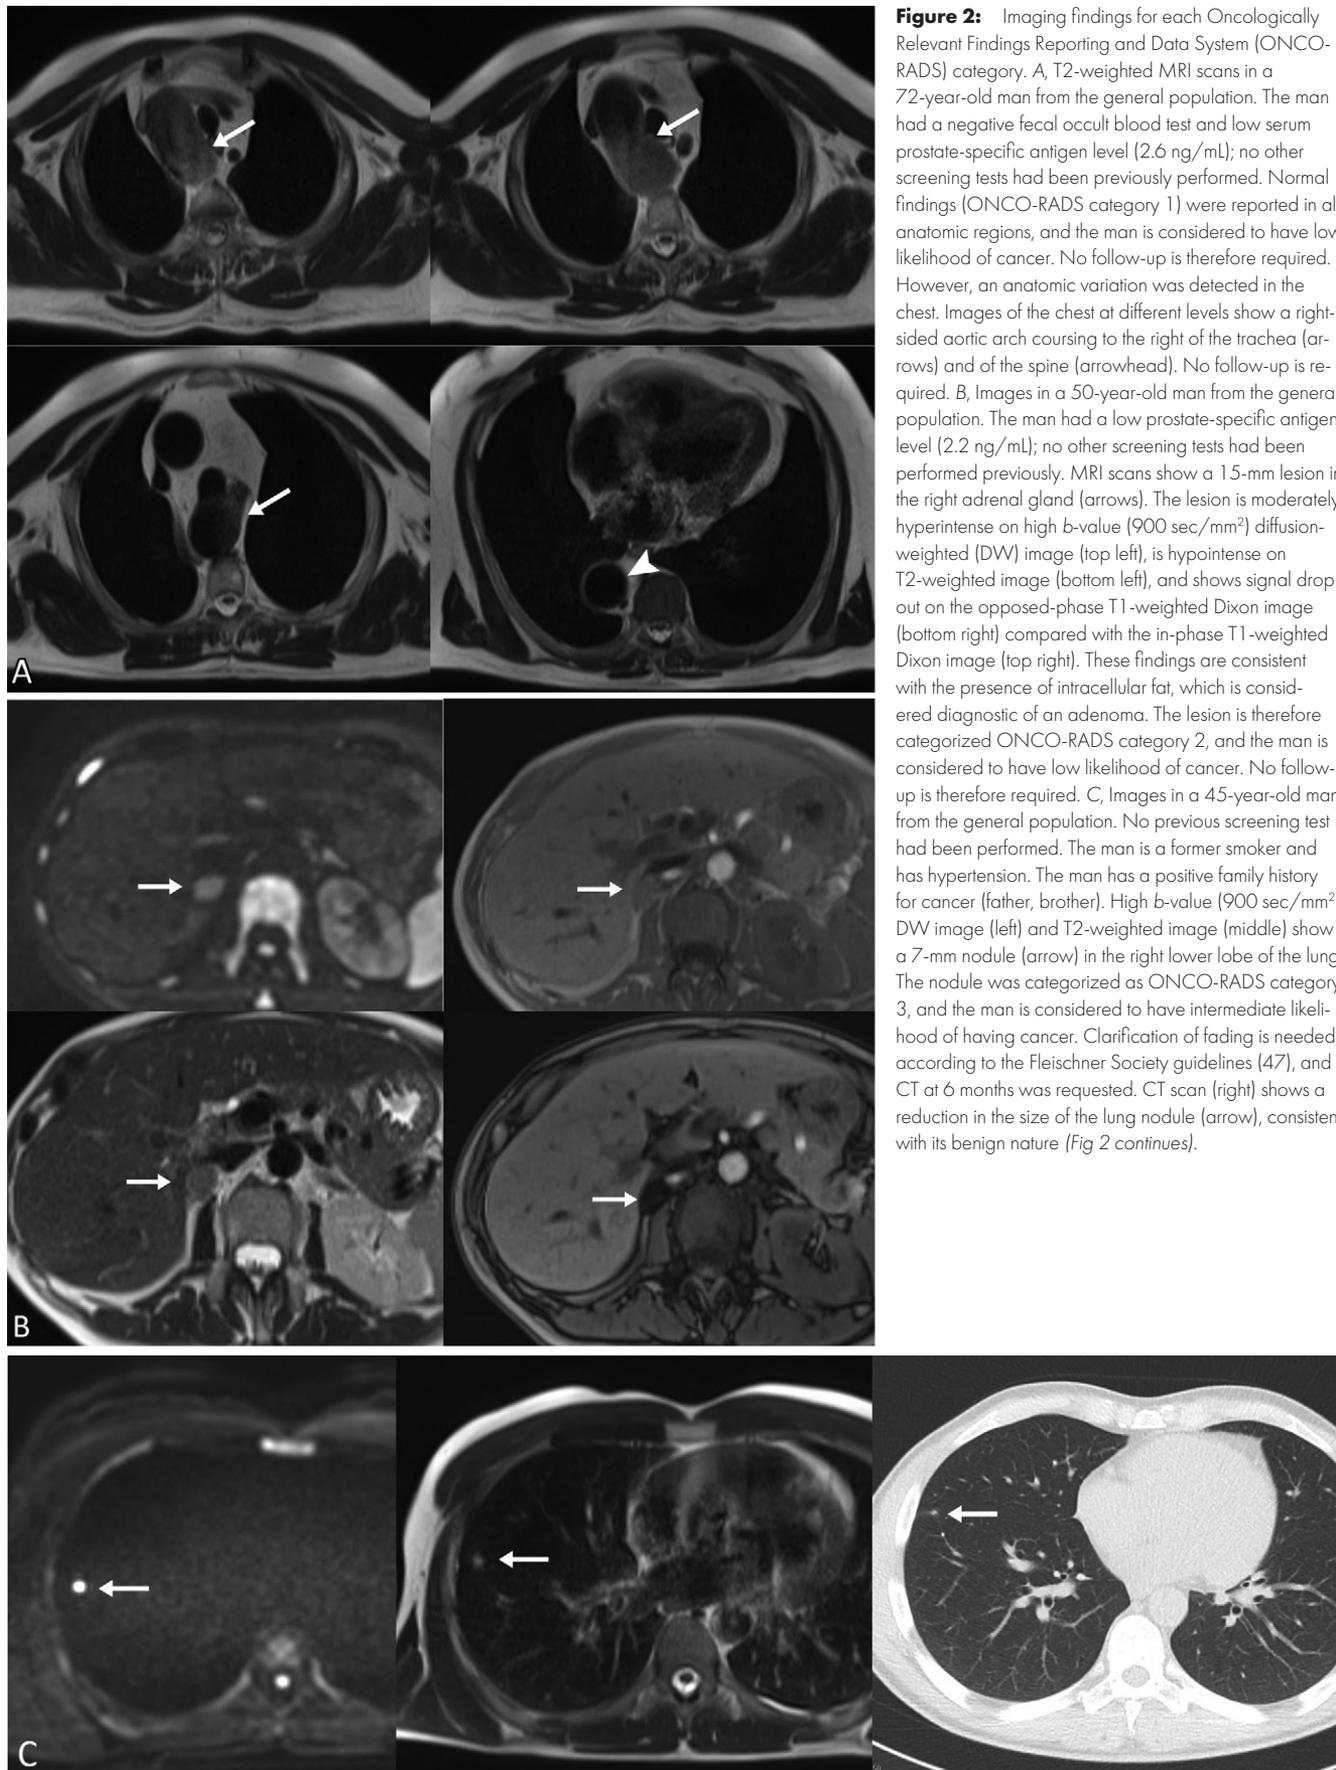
Imaging findings for each Oncologically Relevant Findings Reporting and Data System (ONCO-RADS) category. A, T2-weighted MRI scans in a 72-year-old man from the general population. The man had a negative fecal occult blood test and low serum prostate-specific antigen level (2.6 ng/mL); no other screening tests had been previously performed. Normal findings (ONCO-RADS category 1) were reported in all anatomic regions, and the man is considered to have low likelihood of cancer. No follow-up is therefore required. However, an anatomic variation was detected in the chest. Images of the chest at different levels show a right-sided aortic arch coursing to the right of the trachea (arrows) and of the spine (arrowhead). No follow-up is required. B, Images in a 50-year-old man from the general population. The man had a low prostate-specific antigen level (2.2 ng/mL); no other screening tests had been performed previously. MRI scans show a 15-mm lesion in the right adrenal gland (arrows). The lesion is moderately hyperintense on high b-value (900 sec/mm²) diffusion-weighted (DW) image (top left), is hypointense on T2-weighted image (bottom left), and shows signal drop out on the opposed-phase T1-weighted Dixon image (bottom right) compared with the in-phase T1-weighted Dixon image (top right). These findings are consistent with the presence of intracellular fat, which is considered diagnostic of an adenoma. The lesion is therefore categorized ONCO-RADS category 2, and the man is considered to have low likelihood of cancer. No follow-up is therefore required. C, Images in a 45-year-old man from the general population. No previous screening test had been performed. The man is a former smoker and has hypertension. The man has a positive family history for cancer (father, brother). High b-value (900 sec/mm²) DW image (left) and T2-weighted image (middle) show a 7-mm nodule (arrow) in the right lower lobe of the lung. The nodule was categorized as ONCO-RADS category 3, and the man is considered to have intermediate likelihood of having cancer. Clarification of fading is needed; according to the Fleischner Society guidelines (47), and CT at 6 months was requested. CT scan (right) shows a reduction in the size of the lung nodule (arrow), consistent with its benign nature (Fig 2 continues).
